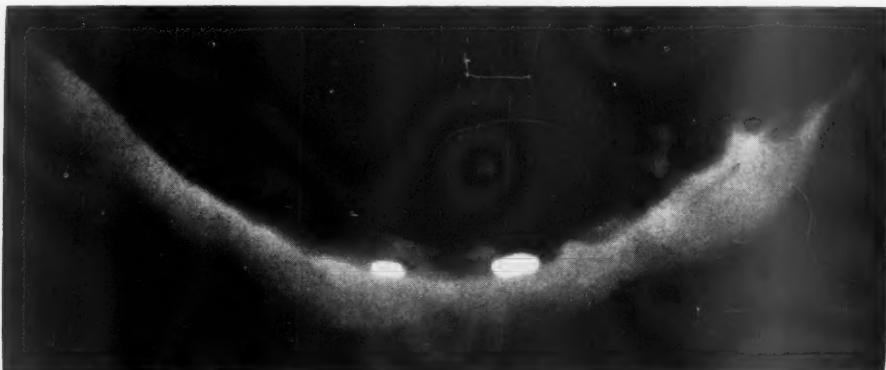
Lateral radiograph of a placenta suspended by its membranes from a wire loop 7" in diameter; the foetal surface is uppermost. The inner surface of the placenta can be easily seen; two small pieces of lead have been placed on the surface to make its identification certain.
